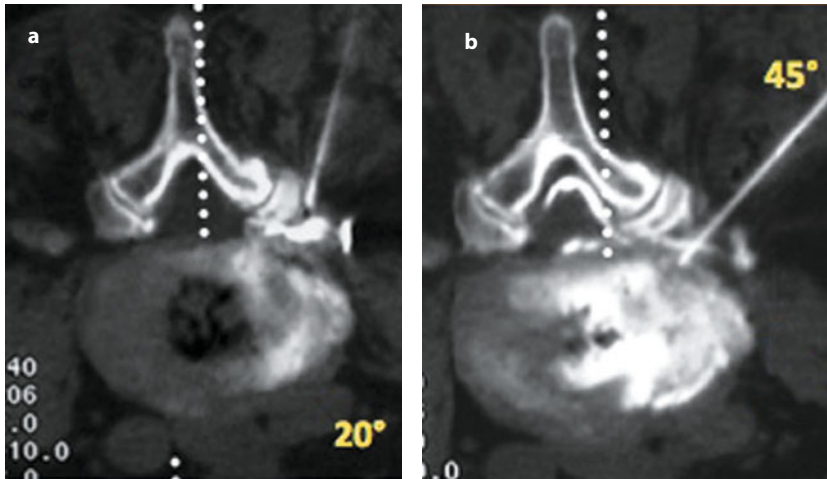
CT showing a spinal needle being inserted at 20° inclination, and the injection is limited to the periganglionic region (a). When the angle is increased to 45°, the contrast medium is spread in the peridural space; an amount of contrast enters the intervertebral disk (b)
